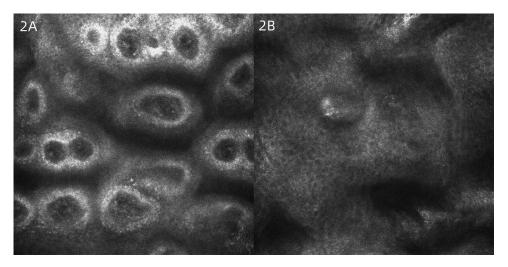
(A and B) Skin CT: Compared to the surrounding normal skin, the pigment ring in the basal layer of the leukoplakic area was completely absent, and no inflammatory cell infiltration was seen in the dermal papillae, with clear boundaries to the surrounding normal skin.
